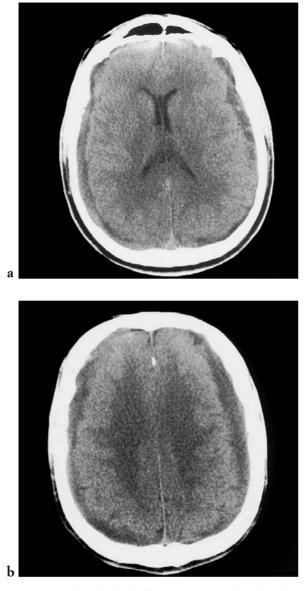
Bilateral subdural haematomas. Axial CT shows bilateral hypodense subdural haematomas. [a), b) axial CT].
